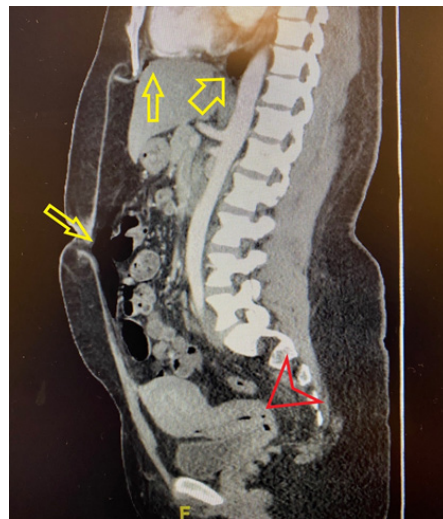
Coronal view of CT abdomen/pelvis demonstrating pneumoperitoneum with multiple foci of free air under the diaphragm and around the liver (arrows).
